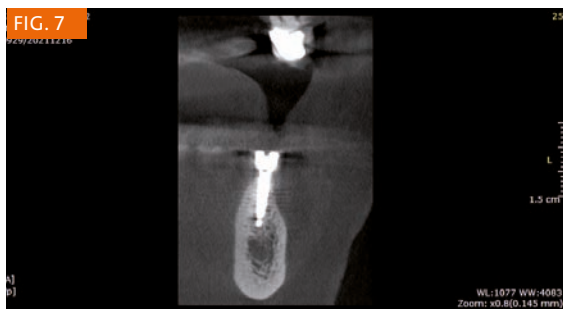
CBCT after 6 months (coronal section in position 3.6).
